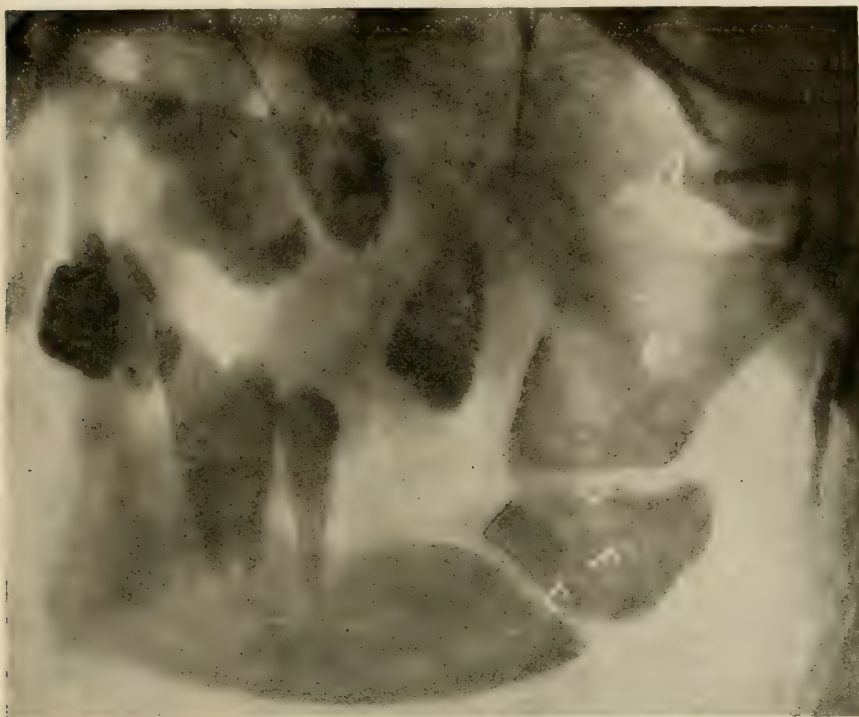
Double comminuted fracture of the mandible. That the reader may understand the picture, observe the following: A, zygomatic arch; B, sigmoid notch; C, upper part of ramus; D, one fracture; E, the other fracture; F, fragment of bone between fractures. (Radiograph grossly retouched.)
